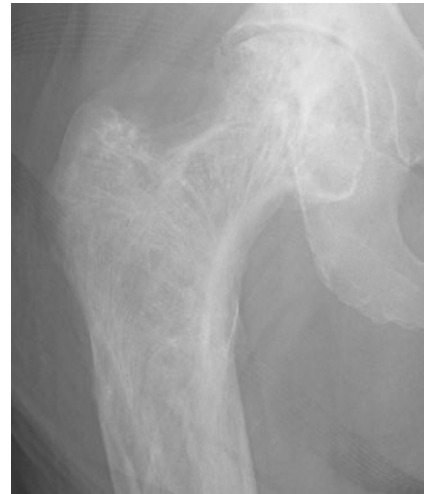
Magnification view of frontal right hip radiograph
